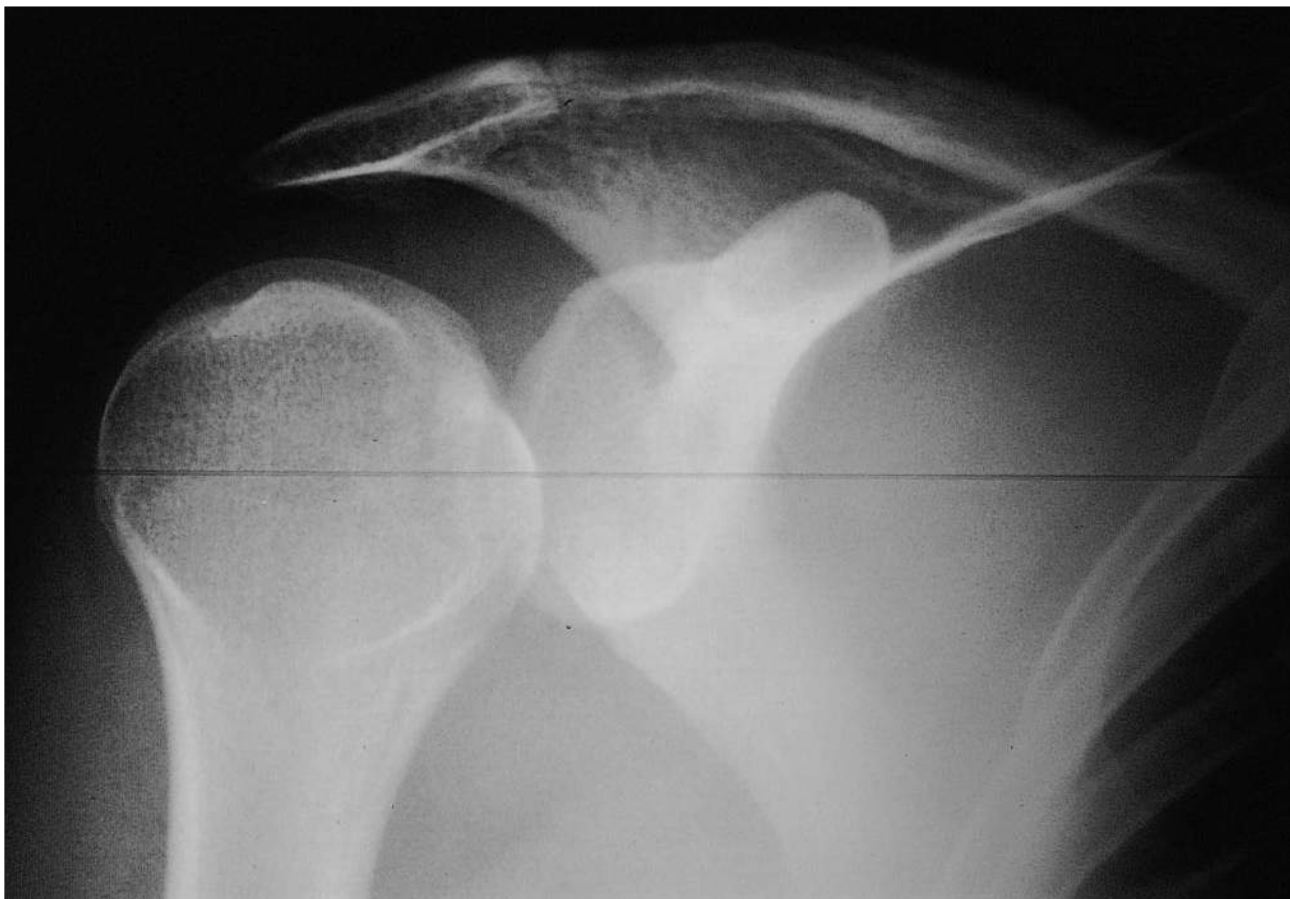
■ Posterior Shoulder Dislocation. AP radiograph of this rare type of shoulder dislocation. Because of internal rotation of the greater tuberosity, the humeral head appears like a dip of ice cream on a cone, thus called the “ice cream cone sign.” (Photo contributor: Alan B. Storrow, MD.)
